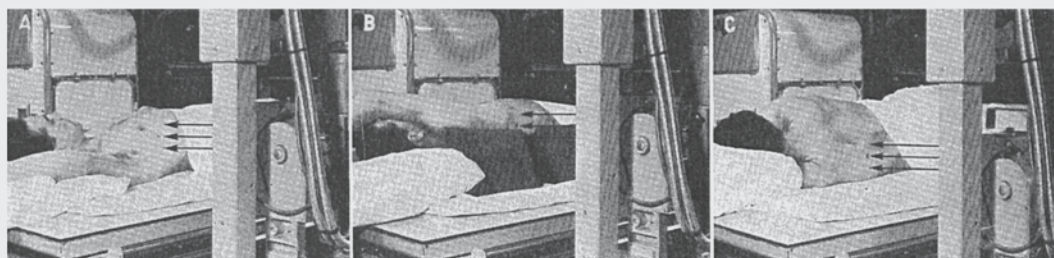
Radiographic Positioning.* (A) Lateral, (B) LAO 70°, (C) RAO 20°, to the lateral changer. All films are taken single plane, with a horizontal beam. Technical factors: 1,000 mA, 0.010 sec. (10 mAs); 80-95 kV; 38-in. distance; high-speed screens; Kodak Royal Blue film; 12:1 100 line grid; 1-mm spot—Dynamax 61 tube.
